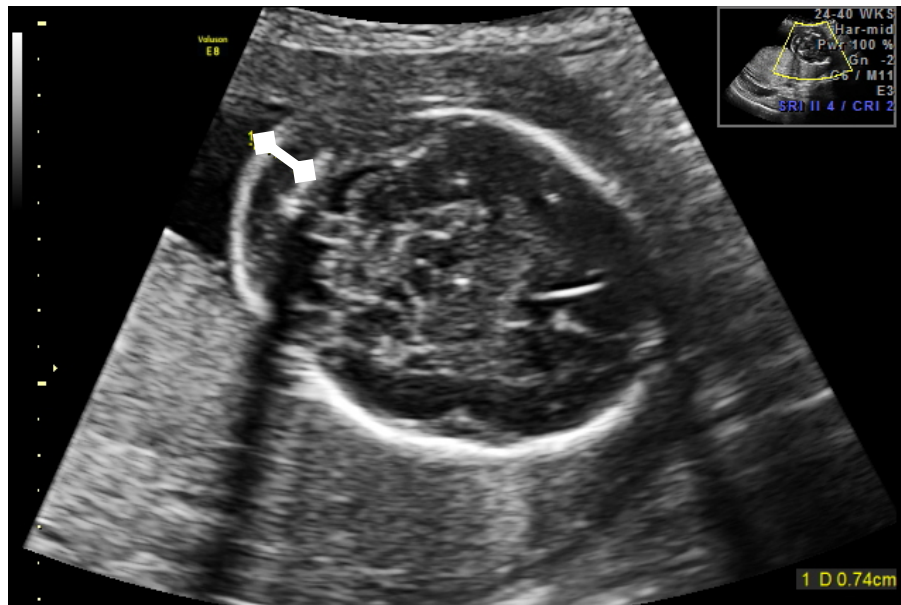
Ultrasound measurement of nuchal skin fold (NSF) thickness. Ultrasound image at 19 weeks, 6 days (personal communication, Alan Donnerfeld, MD). The white oval visible in the center of the image is a cross-sectional view of the fetal skull. The white bar in the upper left quadrant indicates the NSF measurement of 7.4 mm. In most centers, this would be considered a positive NSF measurement
